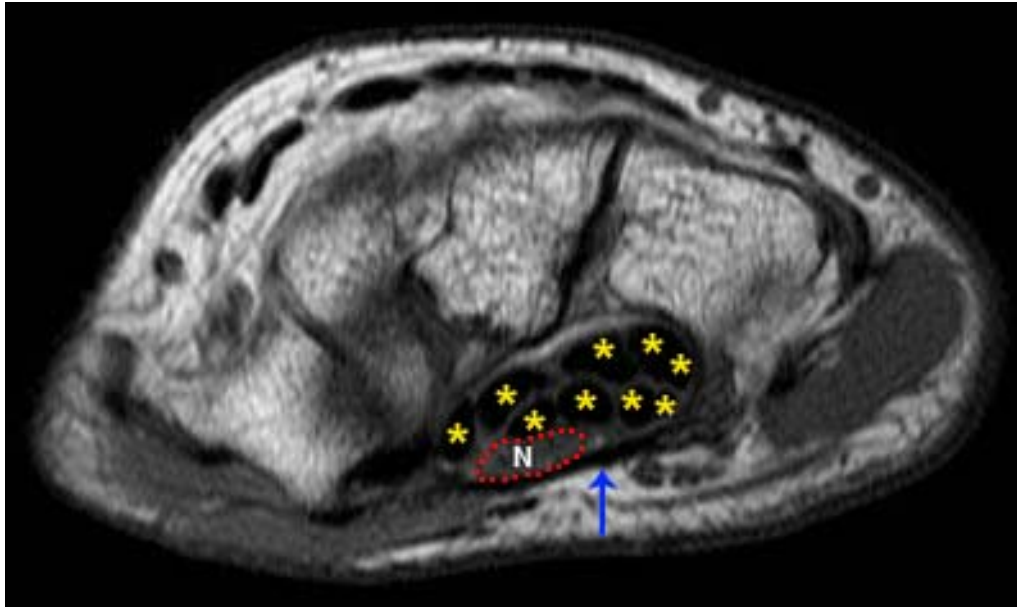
T1-weighted MR image through the carpal tunnel.<sup>47</sup> Dark tendons are indicated with yellow asterisks, the textured nerve (N) is outlined in a red dotted line, and the dark transverse carpal ligament is indicated by the blue arrow.
